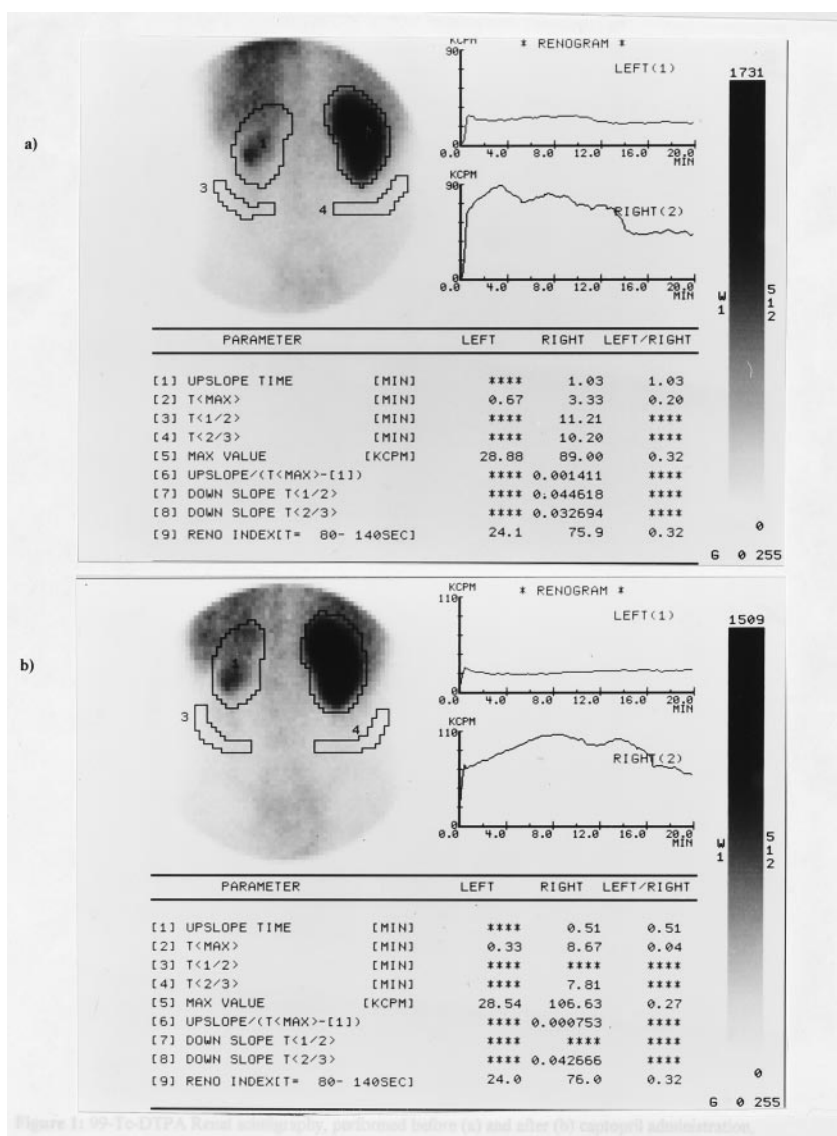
99-Tc-DTPA renal scintigraphy, performed before (a) and after (b) captopril administration, showed a small-sized left kidney with hypoperfusion.
